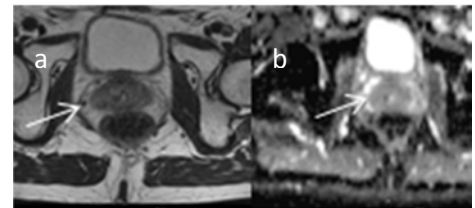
a&b: same patient as Fig 1. Fig 2 shows T2w (a) & DWI (b) at the 6 months interval following CIT. The focal lesion is no longer delimitable.
